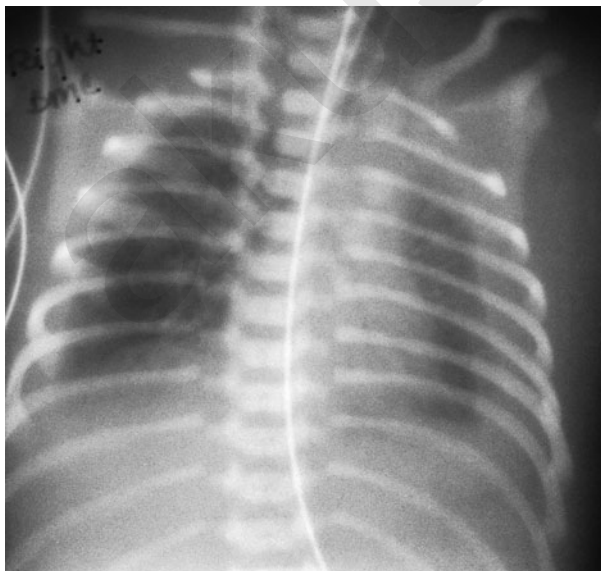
Chest x-ray in a term neonate demonstrating bilateral chylothorax.
